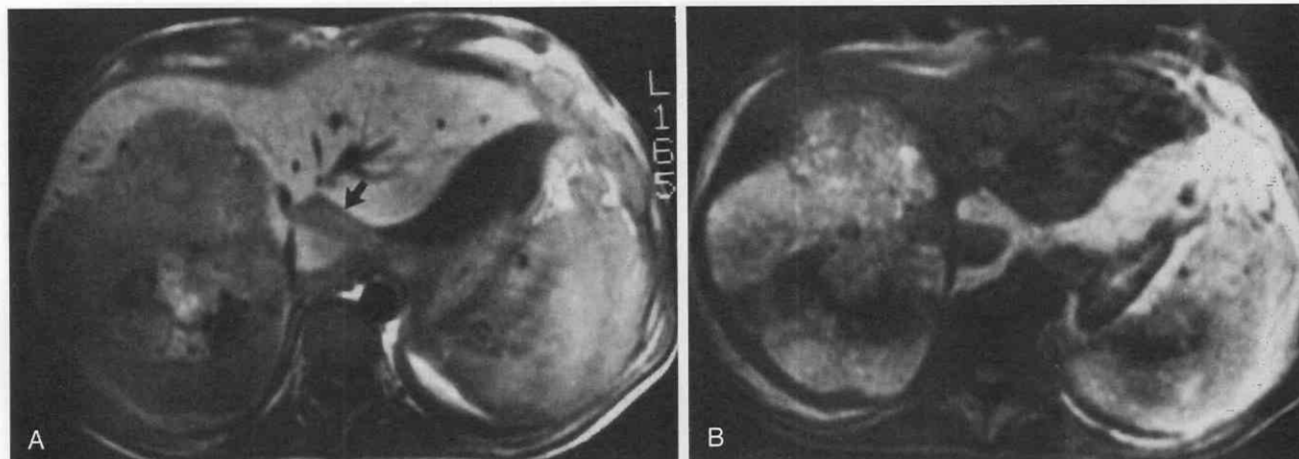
Hepatocellular carcinoma in a 46-year-old man. *A*, Fat-suppression T1-weighted image (TR = 550 msec, TE = 20 msec) reveals the large mass to be predominantly hypointense with central hemorrhage of mixed signal intensity. Regional extension of tumor is present (*arrow*). *B*, T2-weighted image (TR = 2500 msec, TE = 80 msec) reveals the heterogeneous hyperintense mass with low signal intensity in the region of hemorrhage, indicating the presence of hemosiderin. The signal intensity of the ascitic fluid is higher than that of the area of regional spread.
